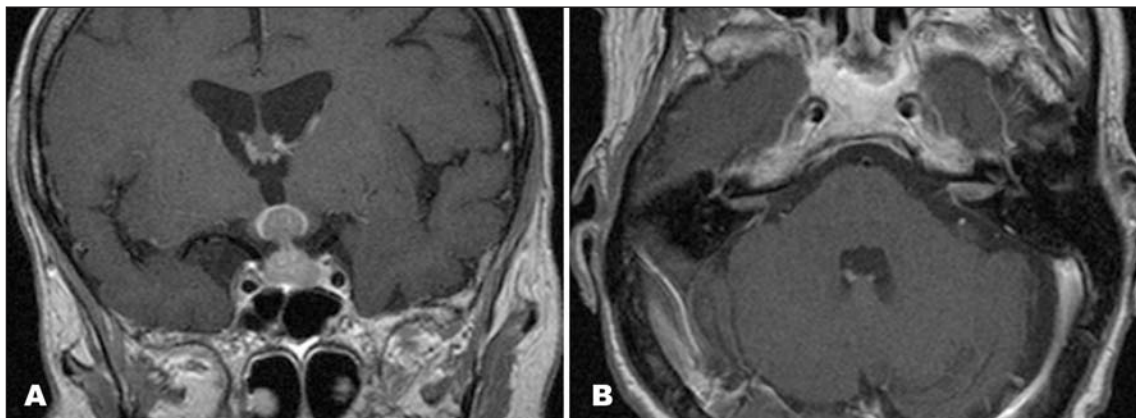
Cranial gadolinium-enhanced T1-weighted MRI. (A) Coronal image showing tumour extension to the hypothalamus. (B) Axial image showing bilateral CPA lesions.
